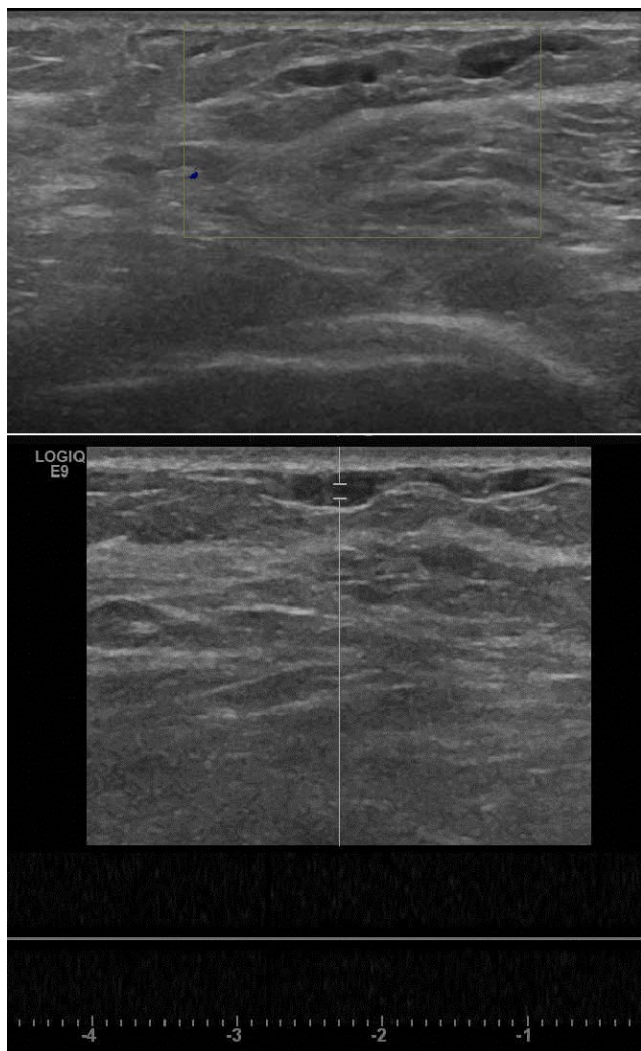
Sonography of the right breast reveals an anechoic bead-like structure in the upper outer quadrant of the right breast. No blood flow can be demonstrated by color Doppler ultrasonography [Color figure can be viewed at wileyonlinelibrary.com]
